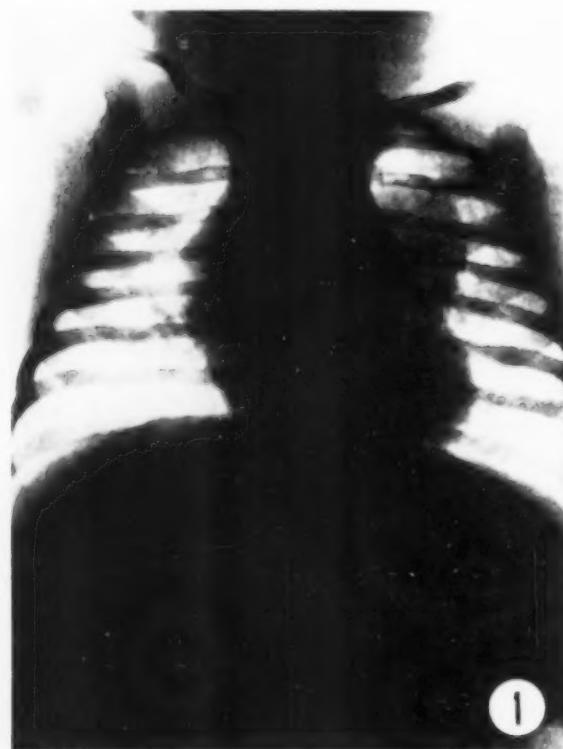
X-ray of lungs: P.A. view: Shows large oval mediastinal mass in left upper zone.
